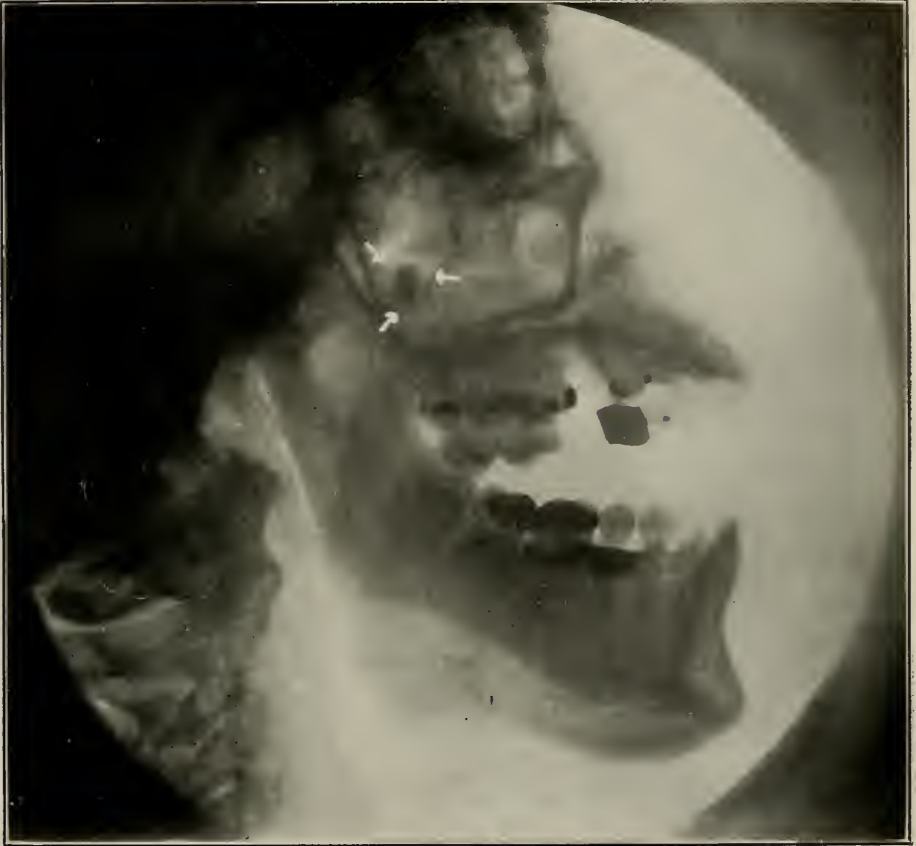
The more or less oval shadow at which the arrows point is a piece of tooth root in the antrum. (Radiograph by Carman, of St. Louis, Mo.)
